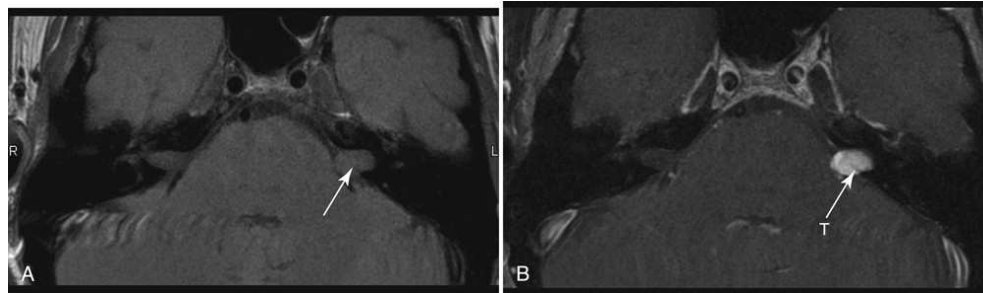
Axial magnetic resonance imaging of the brain in a patient with an acoustic nerve tumor arising from the complex of the seventh and eighth cranial nerves. (A) Precontrast T₁-weighted image shows an inhomogeneous area of abnormality (*white arrows*), with mass effect expanding the area of the nerve complex. (B) Image obtained at the same level after gadolinium enhancement. Active tumor (*T*) shows high signal intensity.
